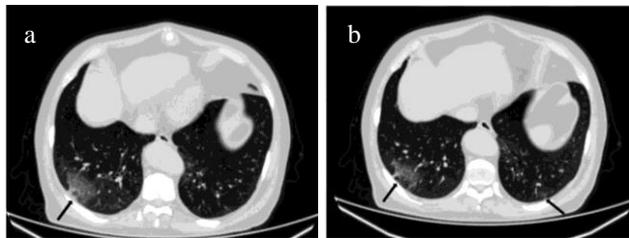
47-year-old male patient who presented with lack of appetite and vomiting. Axial abdominopelvic CT images with lung windows (a, b) show bilateral, peripheral, ground-glass opacities in lung bases (arrows). The patient was found positive for coronavirus disease after abdominopelvic CT findings raised concern for COVID-19.
